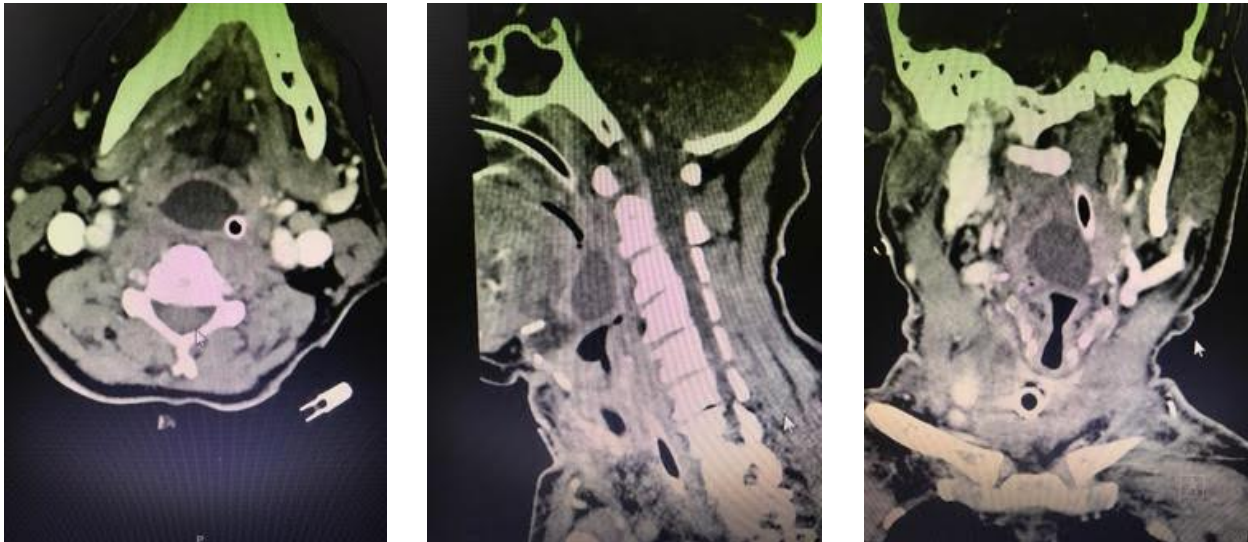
(A,B,C): A-Axial, B-Sagittal and C-coronal views of enhanced CT neck demonstrate left epiglottic simple cystic lesion obstructing the upper airway.
